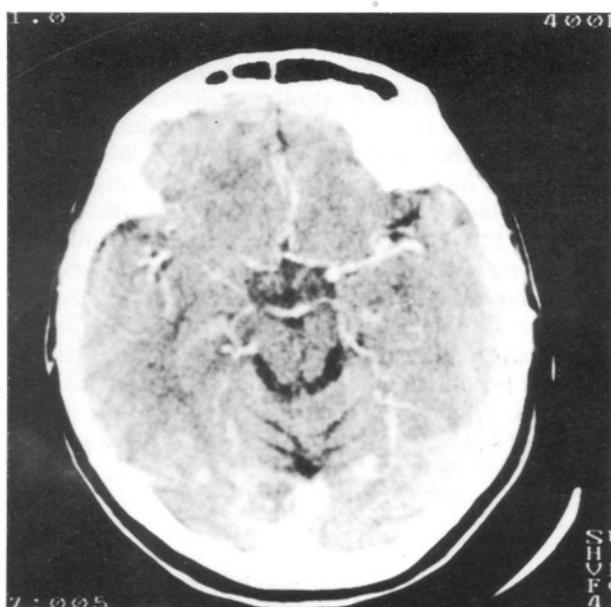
a. Preoperative CT scan of a 56-year-old patient with chronic headache, demonstrating a hyperdense filling at the left MCA bifurcation, b. carotid angiogram revealing an aneurysm of the left MCA bifurcation.
